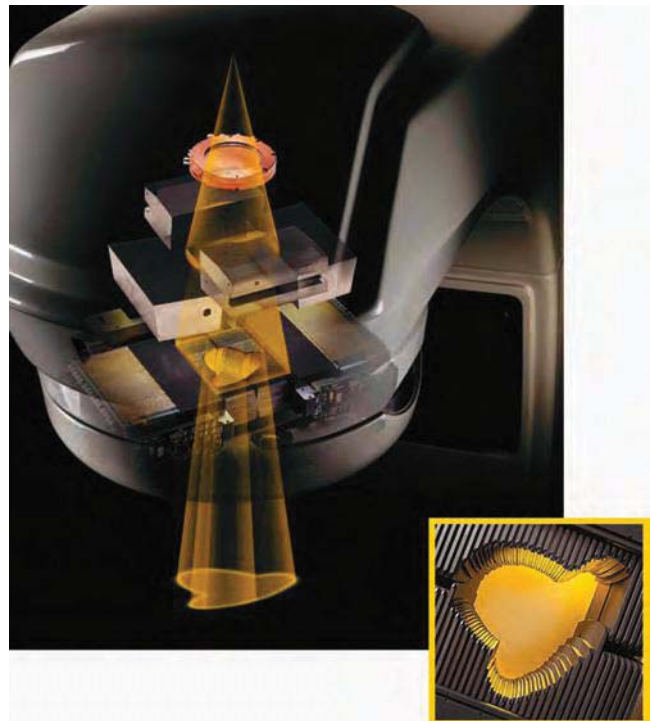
Multileaf collimator shaping of an x-ray treatment beam from a linear accelerator. *Inset* shows a view of the multileaf collimator. (From Varian Medical Systems, Palo Alto, CA, with permission.)
